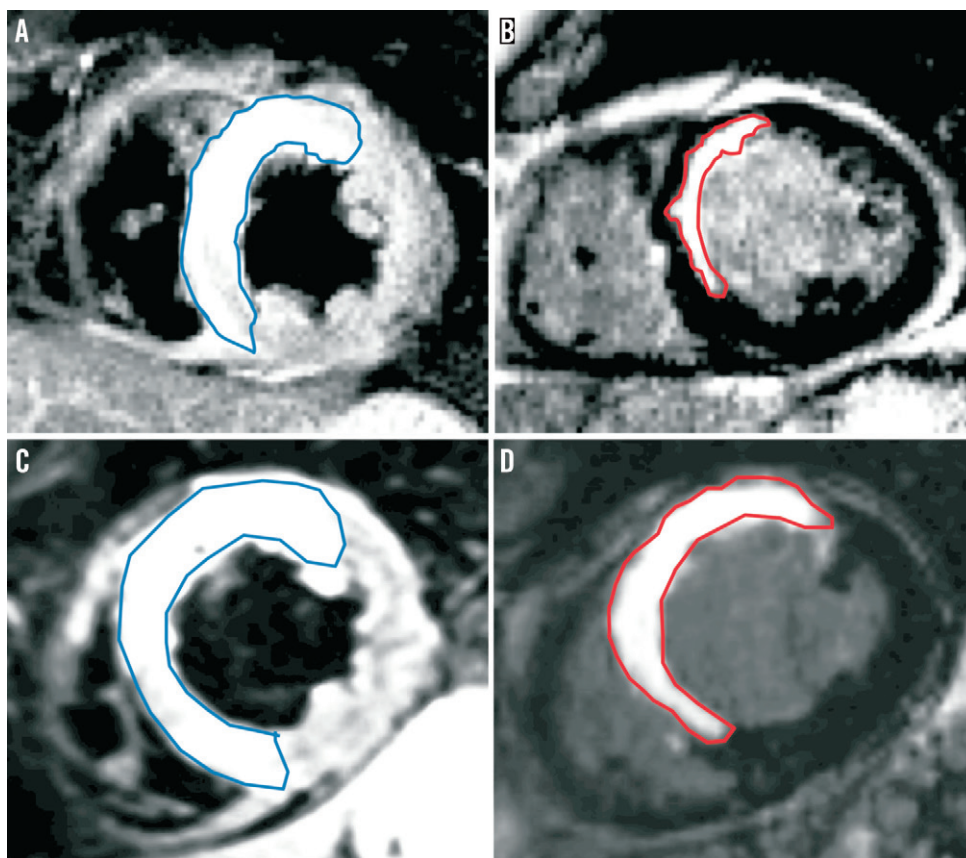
CMR images of two patients with STEMI in the territory of the left anterior descending artery. Left panels (A and C): T2-weighted short-tau inversion-recovery sequence imaged 24 hours after primary PCI to delineate area at risk (blue outline). Right panels (B and D): relatively small (B) and relatively large (D) final infarct size three months later using delayed-enhancement imaging (red outlining).
